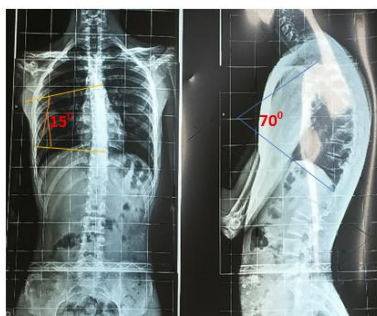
X-ray – Anterior and Lateral Views
